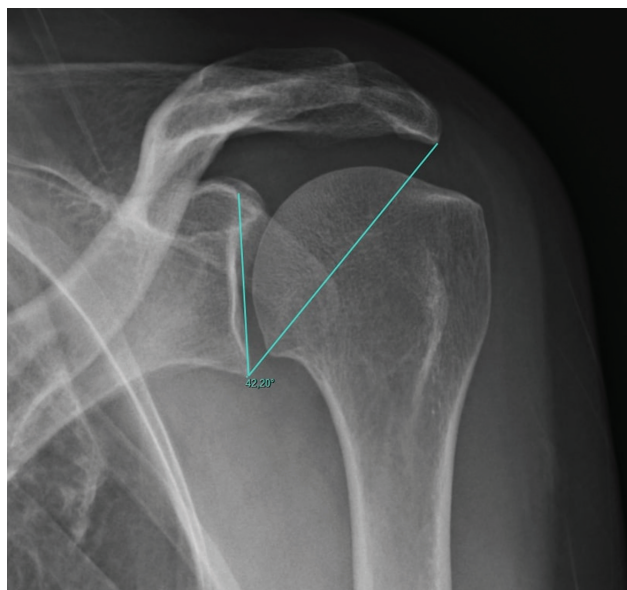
Measurement of the CSA by radiography.
